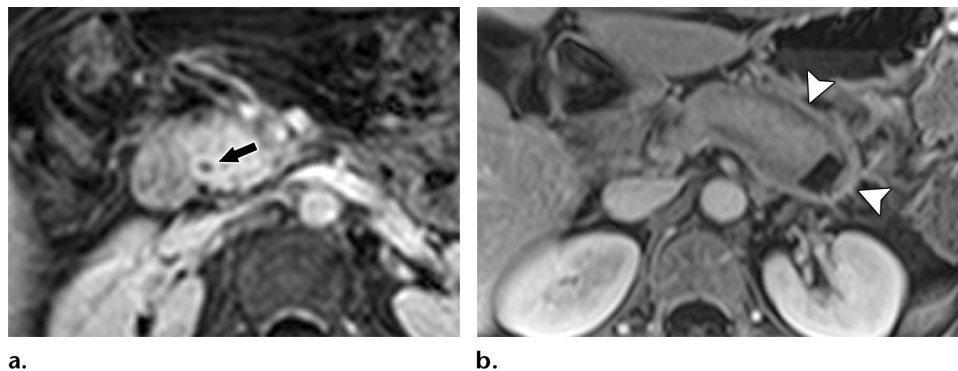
Imaging similarities between IgG4-related sclerosing cholangitis and type 1 autoimmune pancreatitis. (a) Axial contrast-enhanced T1-weighted MR image (portal venous phase) depicts enhancement of the narrowed segment of the common bile duct (arrow) in this 57-year-old man with known IgG4-related sclerosing cholangitis. (b) Axial contrast-enhanced T1-weighted MR image (portal venous phase) shows enhancement of the peripancreatic soft-tissue rim (arrowheads) in a 47-year-old man with type 1 autoimmune pancreatitis. The presence of appreciable fibrosis in both pathologic conditions is thought to be the cause for these findings.
